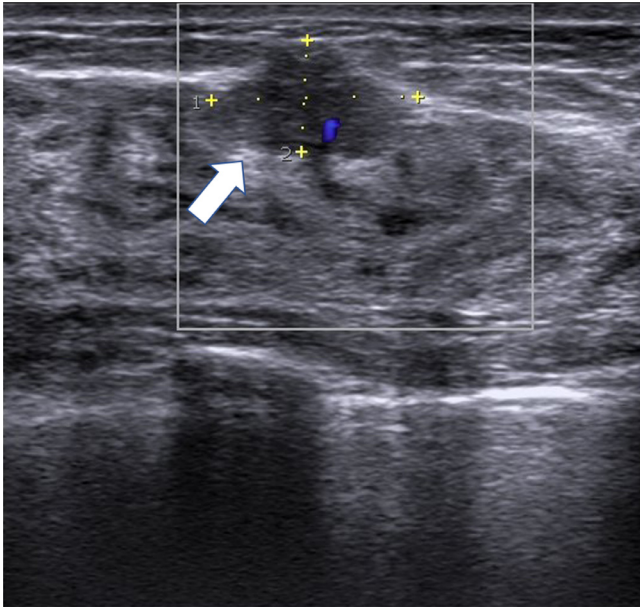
An irregularly shaped hypoechoic mass (arrow) in the left breast was detected using color-Doppler mode ultrasound.
